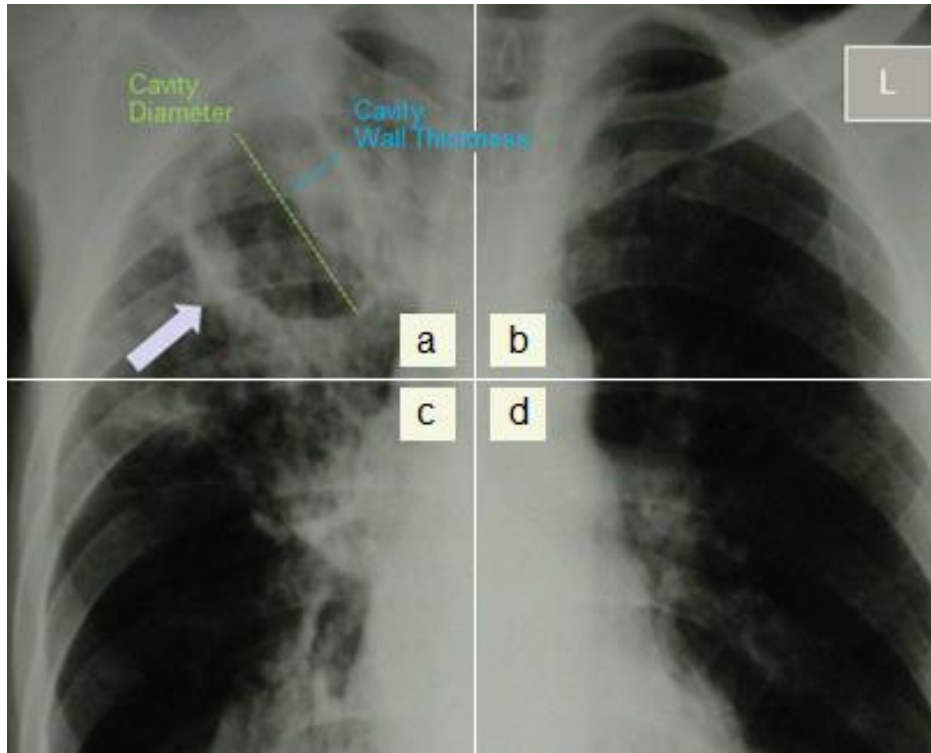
Cavitation and quadrant assessment¹⁰ in posterior anterior chest X-ray
